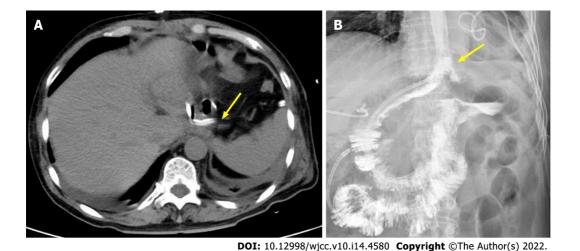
Imaging manifestations after negative pressure drainage via computed tomography. A: Computed tomography showed the drainage tube performed in the thoracic cavity near the leakage of the anastomosis (arrow); B: No anastomotic leakage on fluoroscopic examination (arrow).
